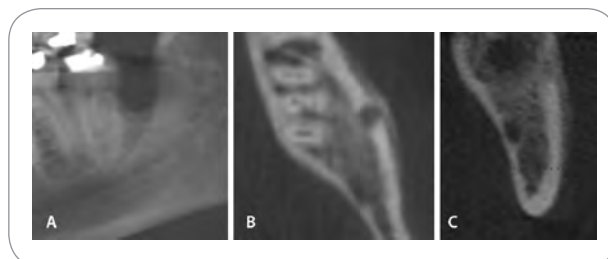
Osteomyelitis following third molar extraction. Data acquired using an iCAT CBCT machine. Images were reformatted in iCATVision software. (A) Reformatted panoramic view shows sclerosis of bone distal to the socket of No. 17. (B and C) Axial and coronal sections through the area of No. 17 show disruption of the buccal cortical plate and periosteal new bone formation.
